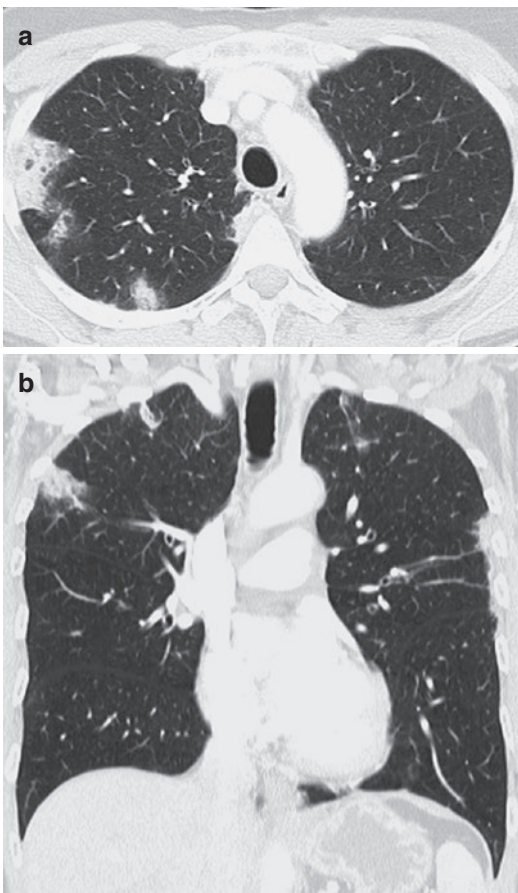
(a, b) Chronic eosinophilic pneumonia in a 56-year-old man presenting with a 4 week history of cough and fever. Moderate blood eosinophilia is found in laboratory workup. Axial CT image shows strikingly peripheral wedge shaped airspace consolidations (a). The upper lobe predominance of the consolidations is displayed on coronal CT image (b)
